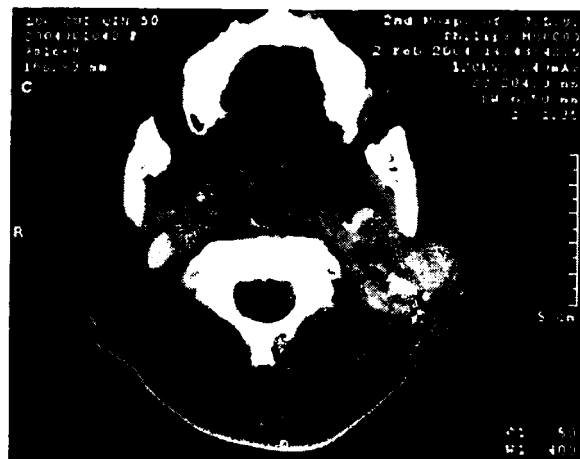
Axial CT of a 50-year-old woman exhibited an irregular mass in the left deep parotid lobe, as well as a smaller mass on the right neck.
